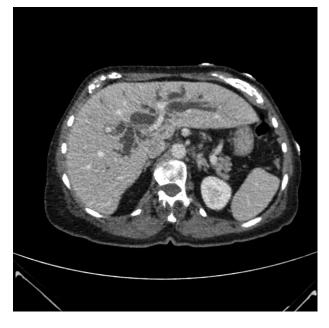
Computed tomography abdomen axial view demonstrating severely dilated left and right intrahepatic ducts.
